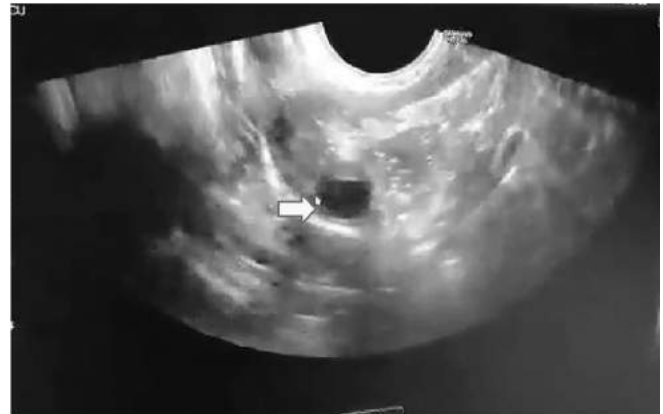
Transrectal sonogram showing the right paraovarian cyst.
